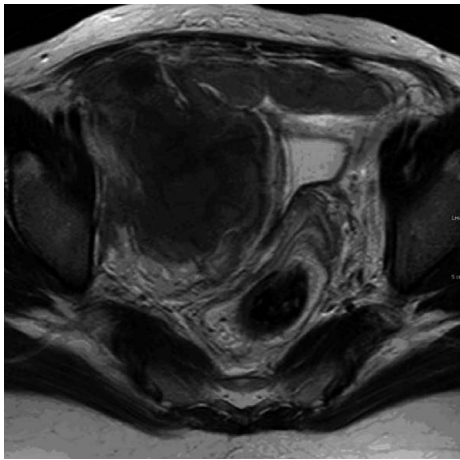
Magnetic resonance image 2 days after embolization. A lobulated hematoma at the right pelvis, from the right side of the perirectal fossa to the right paravesical space, and extending to the prevesical fossa region.
